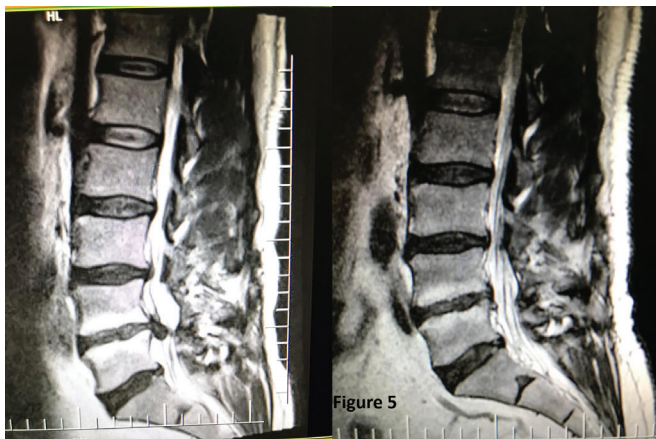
Preoperative and third-month follow-up magnetic resonance imaging of a 46-year-old male patient suffering from recurrent and down-migrated lumbar disc herniation at the L4-5 level, who we successfully treated with transforaminal percutaneous endoscopic lumbar discectomy
